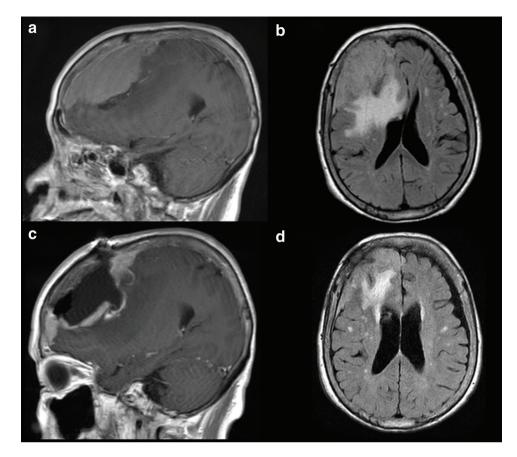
Pre- and postoperative images of the tumor. (a) Preoperative sagittal gadolinium-enhanced T1-weighted MRI showing a thick MEP in the frontal region. (b) Preoperative axial FLAIR MRI, showing marked peritumoral edema and midline shift. (c) Sagittal gadolinium-enhanced T1-weighted MRI with gadolinium taken on postoperative day 6 showing successful tumor volume reduction. (d) Axial FLAIR MRI taken 4 months after the surgery showing resolution of mass effects of the MEP associated with reduced peritumoral edema. FLAIR: fluid-attenuated inversion recovery, MEP: meningioma en plaque, MRI: magnetic resonance imaging.
